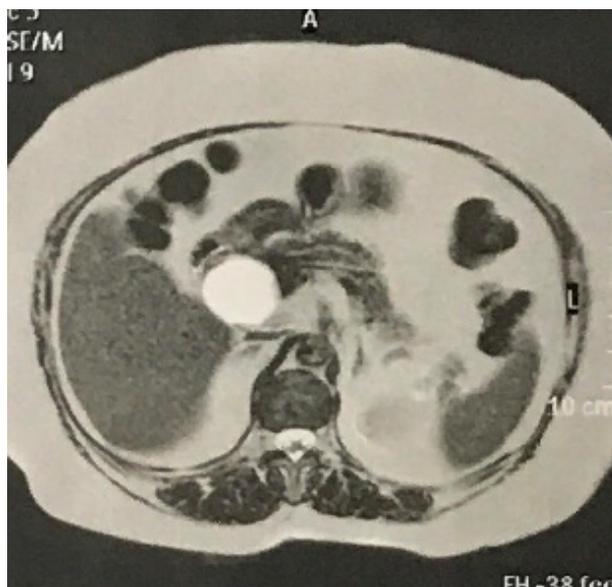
MRI with cystic formation in close contact with the middle/distal third of the choledochal duct of 3.8 x 3.0 cm. Hipersignal in the ponderated sequences in T2
